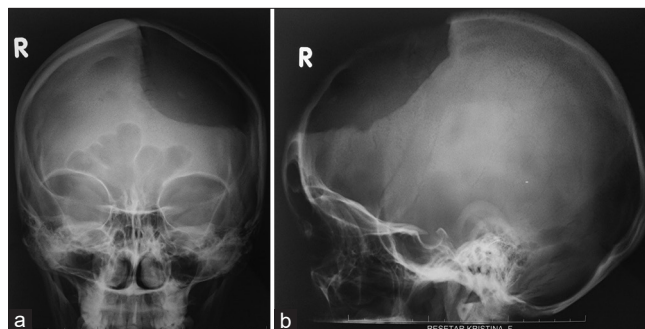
(a) Preoperative plain X-ray craniogram showing unilateral large frontoparietal skull bone defect in AP projection. (b) Preoperative plain X-ray craniogram showing unilateral large frontoparietal skull bone defect in LL projection.
